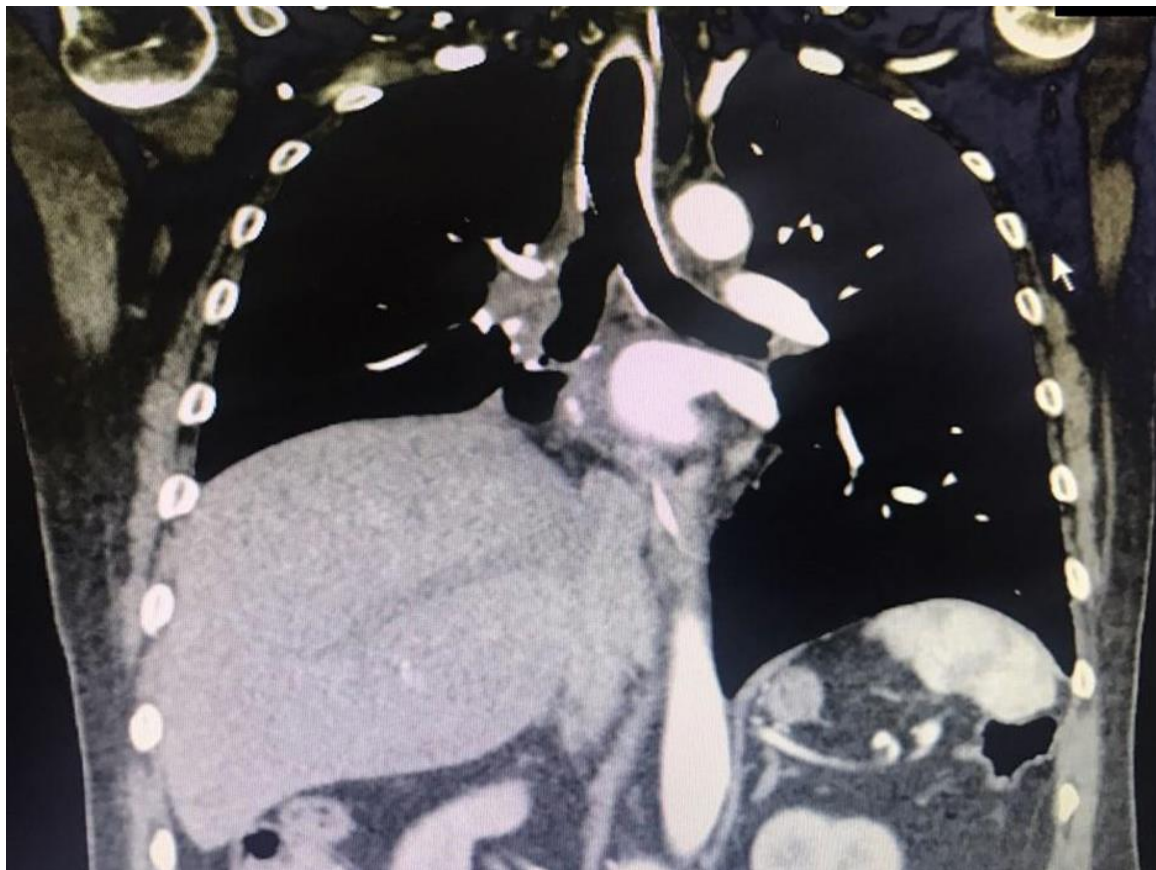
Computed Tomography of thorax showing the stent placement and the reduction of the mediastinal mass after the chemotherapy.
